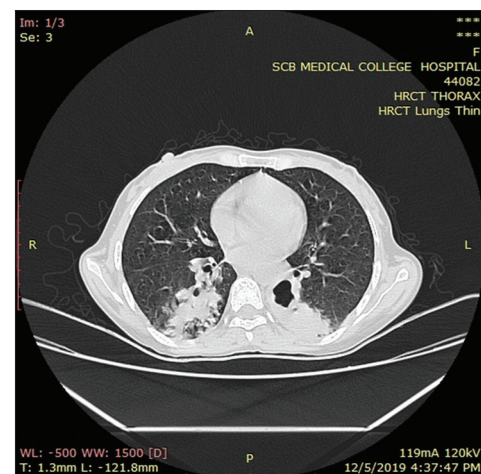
Axial section of high-resolution computed tomography thorax of a 60-year-old male diabetic patient presented with cough showing B/L lower lobe consolidation with the left lower lobe cavitory lesion
